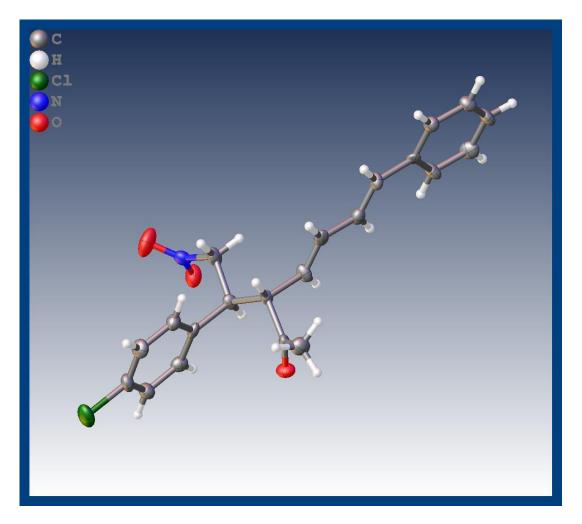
X-Ray image for compound 32Ak.
